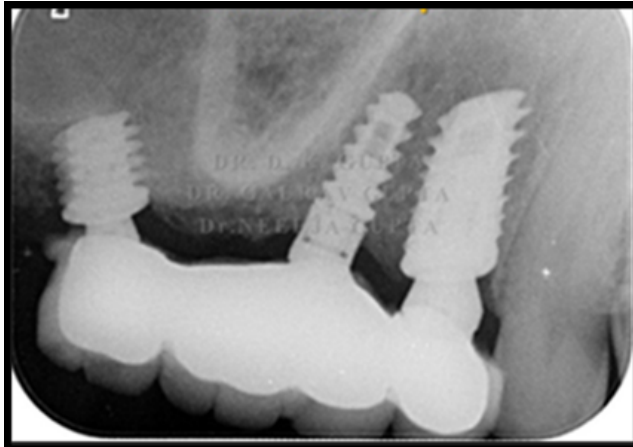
X-ray showing short implant swiss implants placement in posterior maxilla.
